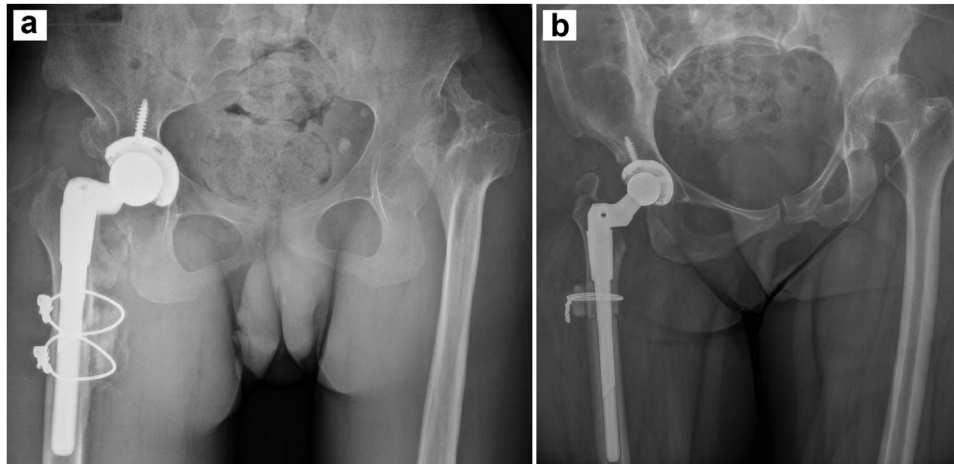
3-month postoperative anteroposterior pelvis radiograph from (a) example patient #1 and (b) example patient #2.
